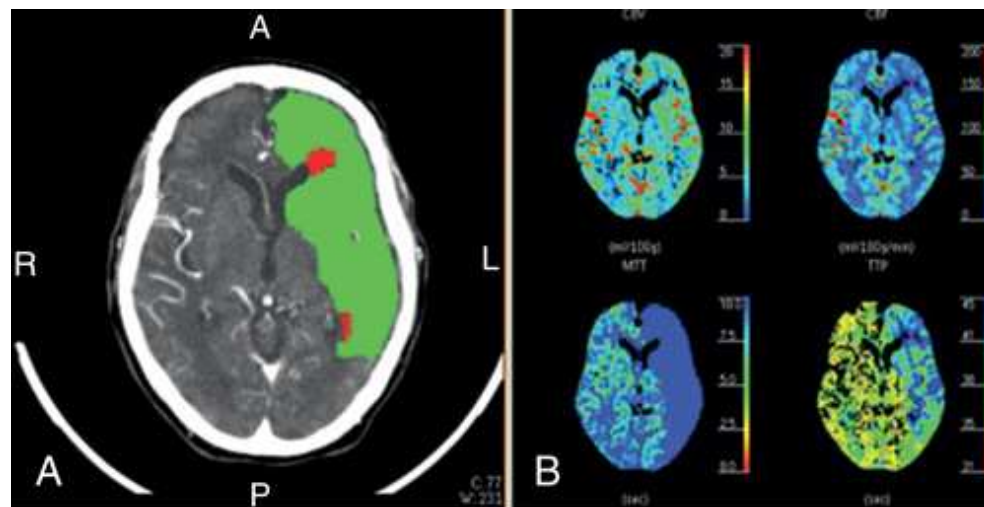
CT brain perfusion study with brain perfusion parameter maps (B) and summary map overlays (A) showing areas of ischemic penumbra (*green*) and infarct (*red*). Images were acquired using a lower dose protocol on a Philips Brilliance CT scanner. Courtesy Philips Medical Systems.
